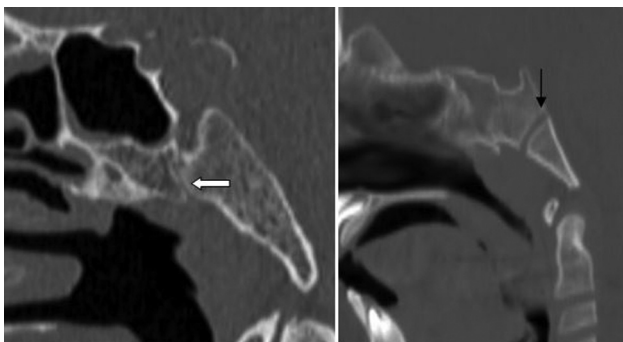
Sagittal computed tomography (CT) scans of the cranio-pharyngeal canal (CC; white arrow) and the spheno-occipital synchondrosis (black arrow).
